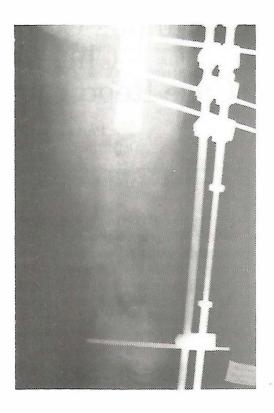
X-rays after resection of 20 cm of femur and stabilization the help of AO tubular external fixator with ilizarov attachment.
